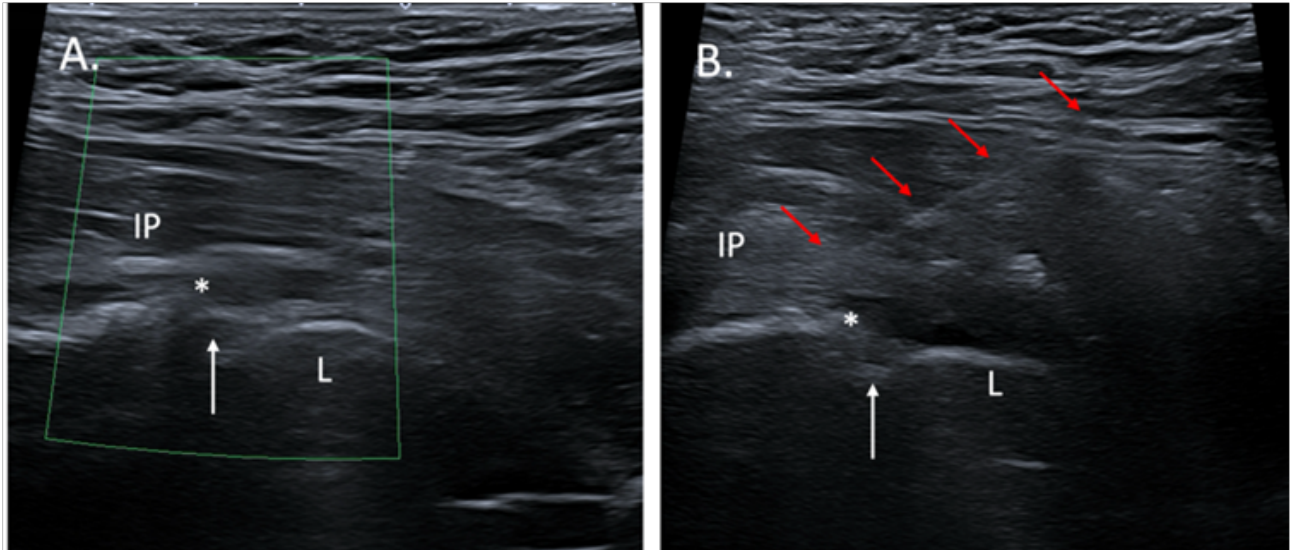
(A): Longitudinal ultrasound images showing the contact between the psoas and the dual mobility liner associated with iliopsoas tendinopathy and bursitis. Acetabulum bone (*) the metallic acetabulum (white arrow), liner (L), and iliopsoas tendon (IP). is evident, associated with iliopsoas tendinopathy and bursitis. 2B.- US guided infiltration for iliopsoas impingement (red arrows).
